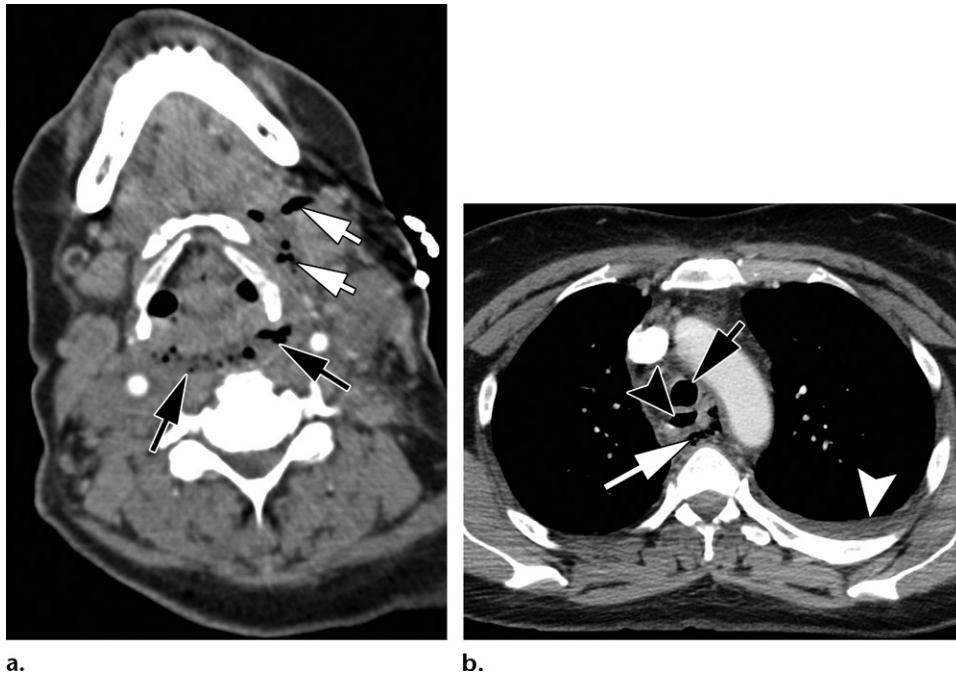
Descending mediastinitis in a 50-year-old woman who recently underwent a dental procedure. (a) Axial contrast-enhanced CT image shows foci of gas and fluid (white arrows) in the left submandibular space, with extension to the danger space (black arrows). (b) Axial contrast-enhanced CT image obtained inferior to a shows continued extension into the mediastinum (white arrow) and a small left pleural effusion (white arrowhead). The trachea (black arrow) and esophagus (black arrowhead) also are seen.
